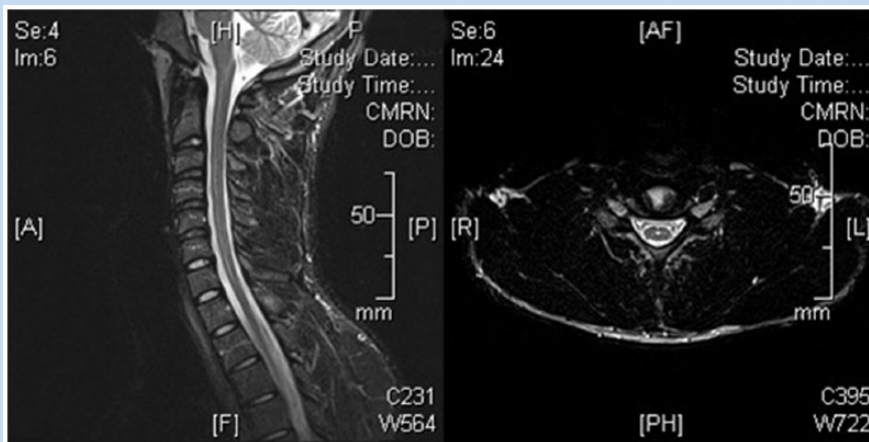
Follow-up magnetic resonance image demonstrating a syrinx in the central canal of the spinal cord.
